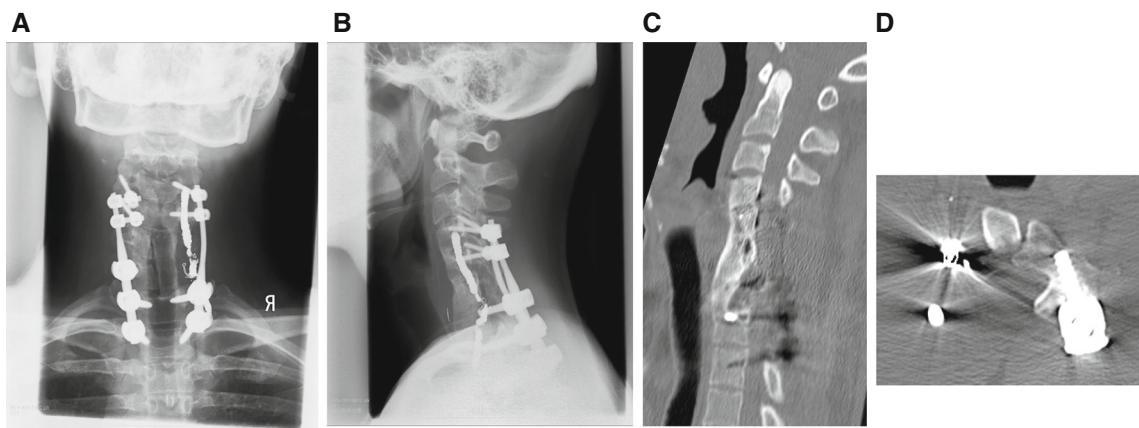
a–d At 2-year follow-up, CT showed bony union and no evidence of recurrence
